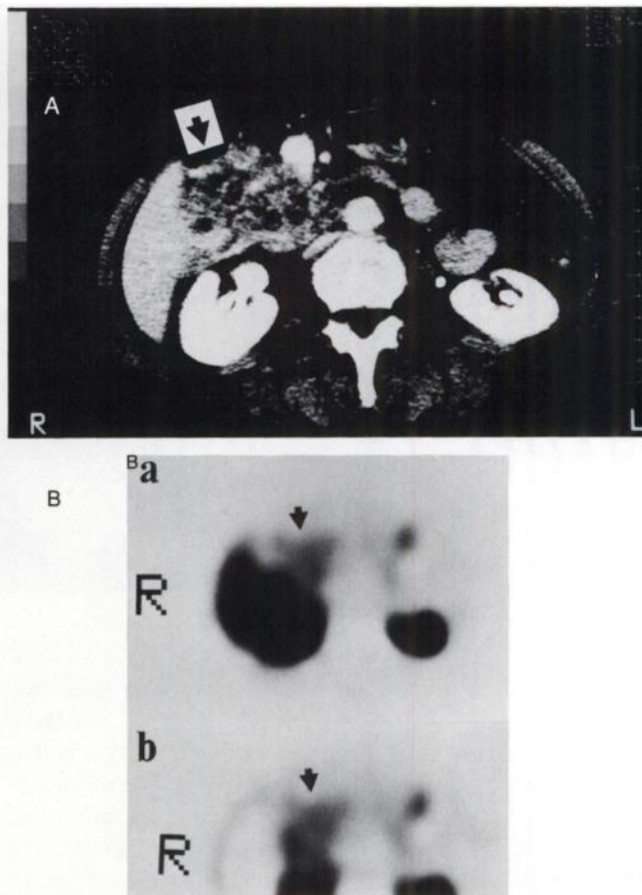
A 73-yr-old female with a serous cystadenoma. (A) Enhanced CT shows a large, markedly enhanced mass composed of numerous cystic lesions (➔), measuring 90 × 55 mm in the pancreatic uncus. (B) Tumor uptake of ^{201}Tl (➔) was not clearly distinguished from liver activity on ^{201}Tl SPECT (a). The subtracted SPECT image (b) subtracted the liver and an abnormal uptake site was clearly visualized (➔). The L/H ratio acquired on the ^{201}Tl SPECT image (a) was relatively 0.51.
